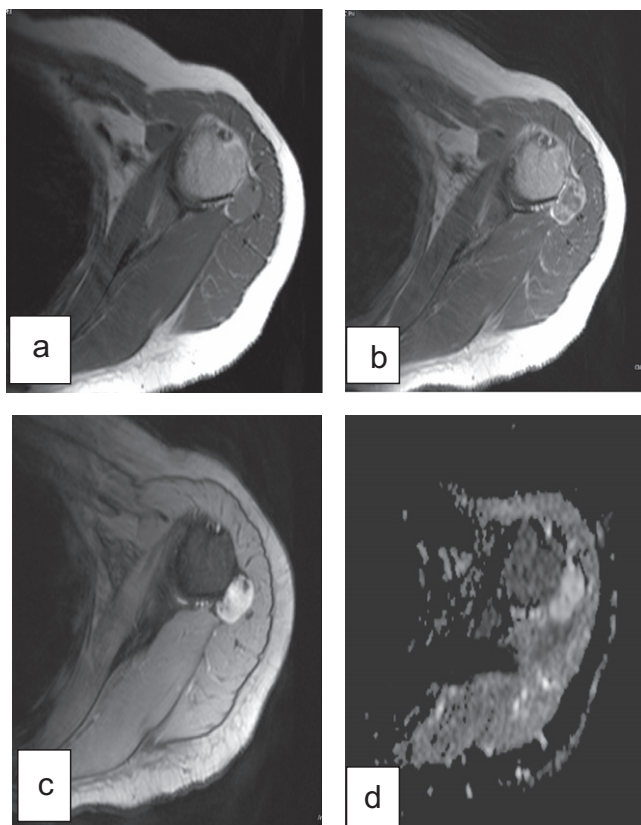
Juxtacortical Enchondroma of the humeral head appears of low signal in axial T1WIs(a), heterogenous high signal in axial T2WIs and fat suppression sequence (b,c), with No restriction in DWI and ADC (d) ADC Value 2.65 ± 0.36 .
